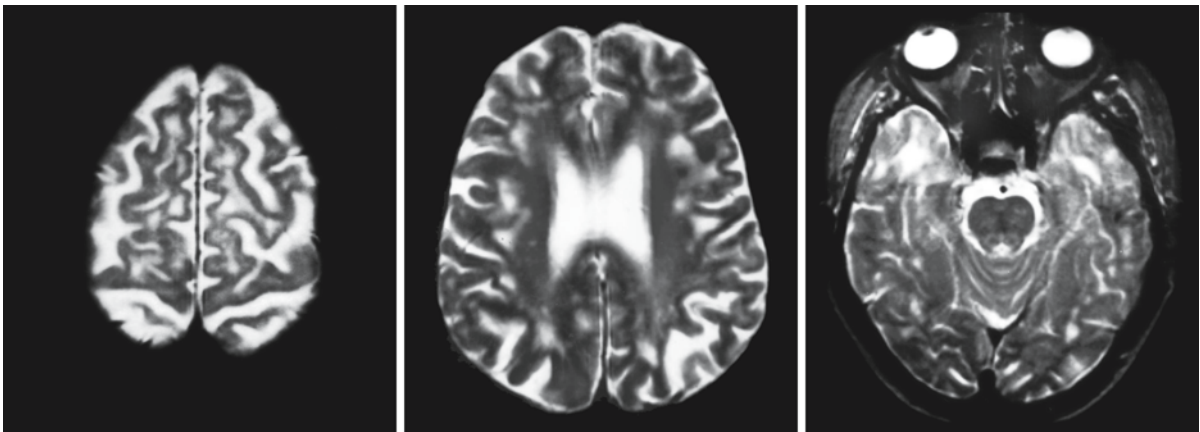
These T₂-weighted MR images show the white matter changes in a 60-year-old female patient with DM 1. The white matter abnormalities are patchy and predominantly located in the subcortical areas. The temporal white matter is
